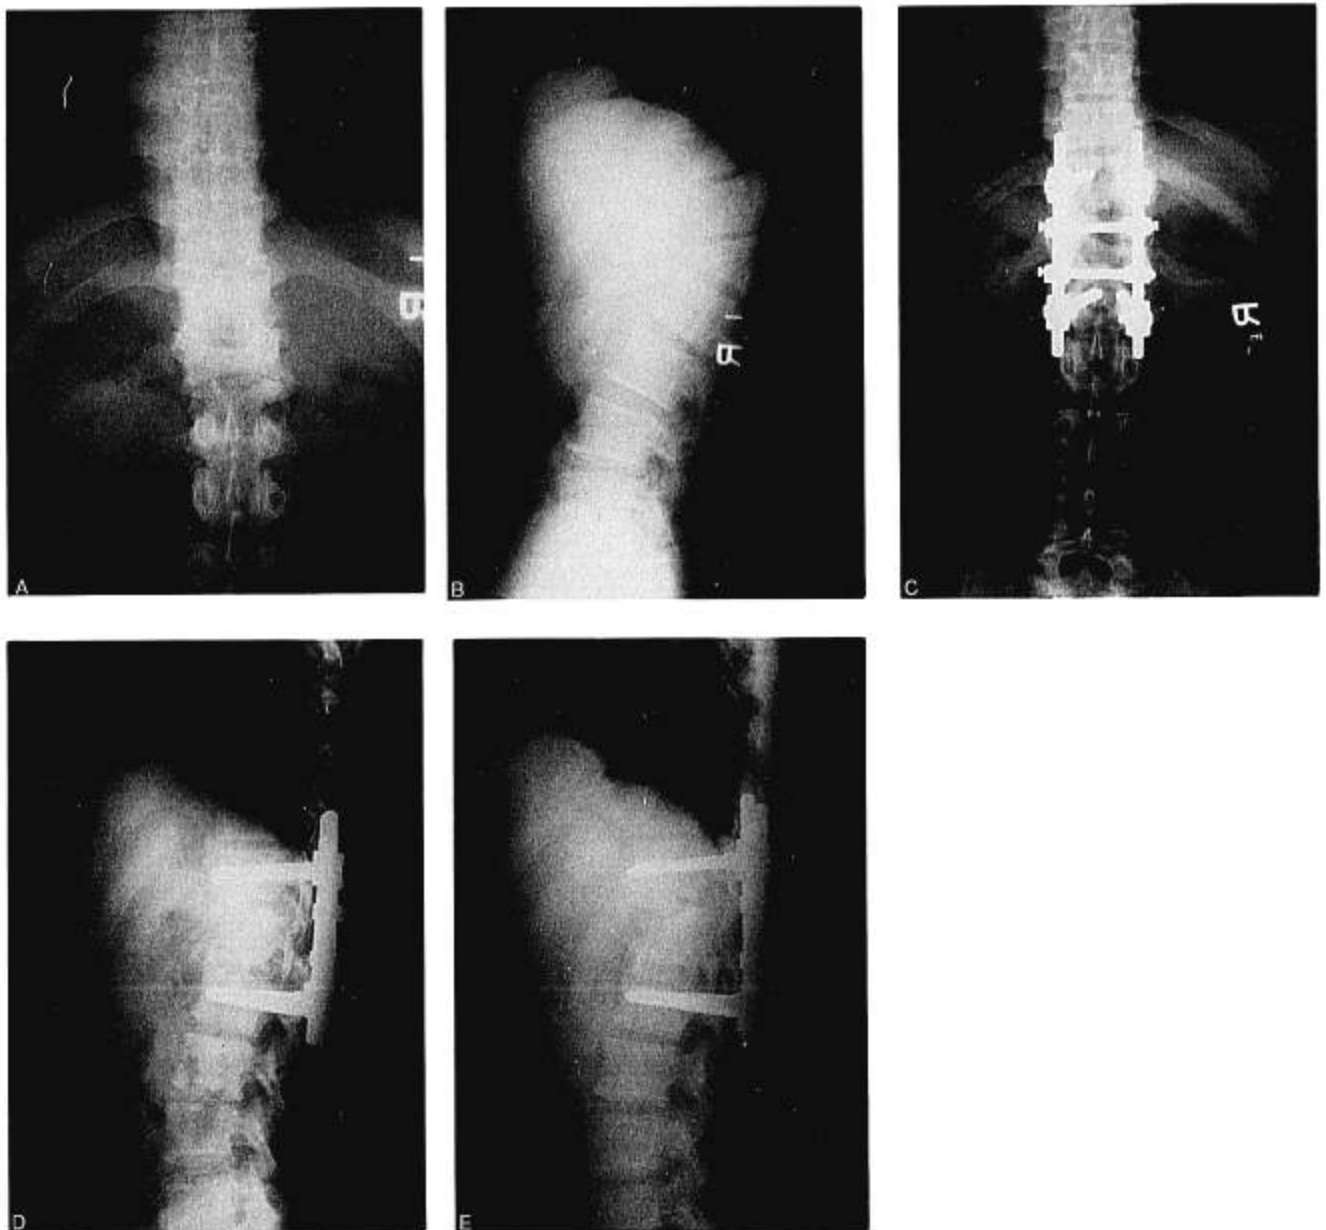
A 35-year-old man had incurred a 12th vertebral fracture 4 years before he presented to our clinic with a rigid thoracolumbar angular kyphosis (Case 7). A and B, Preoperative anteroposterior and lateral radiographs showed the already healed wedged vertebral body and angular kyphosis of 52°. C and D, One month postoperative anteroposterior and lateral films showed bisegmental discectomy, iliac bone grafts, and three-level RF instrumentation. The kyphosis was corrected to a near-straight thoracolumbar junction (7°). In this case, 0° angled pedicle screws were chosen to try to create a straight thoracolumbar junction. E, One-year postoperative film demonstrated solid fusion. The thoracolumbar junction remained straight (8°) with little loss of correction.
